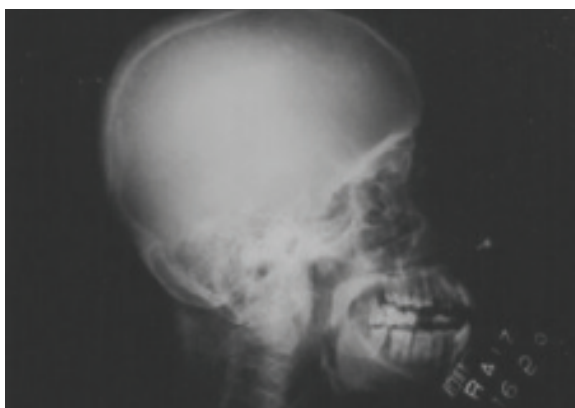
X-ray Skull (lateral) shows diffuse trabecular resorption, giving a granular ‘salt and pepper’ appearance. Loss of distinction between the outer and inner tables of the skull is seen.
